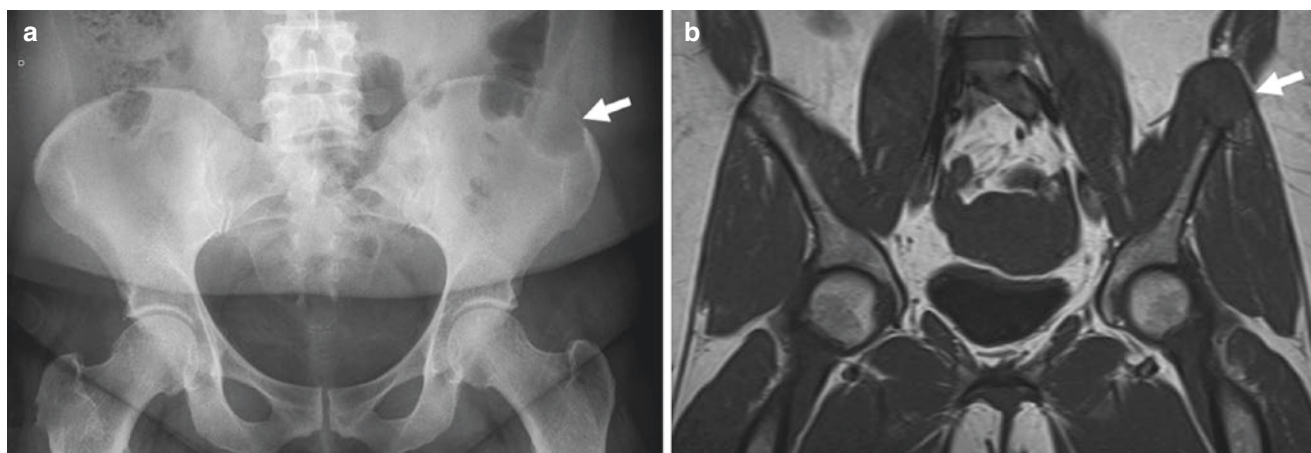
Frontal radiograph of the pelvic demonstrates a lytic lesion in the left iliac wing with a narrow zone of transition (a—arrow). A subsequent coronal T1 MRI image demonstrates the expansile lytic lesion (b—arrow) diagnosed as a giant cell tumor on pathology
